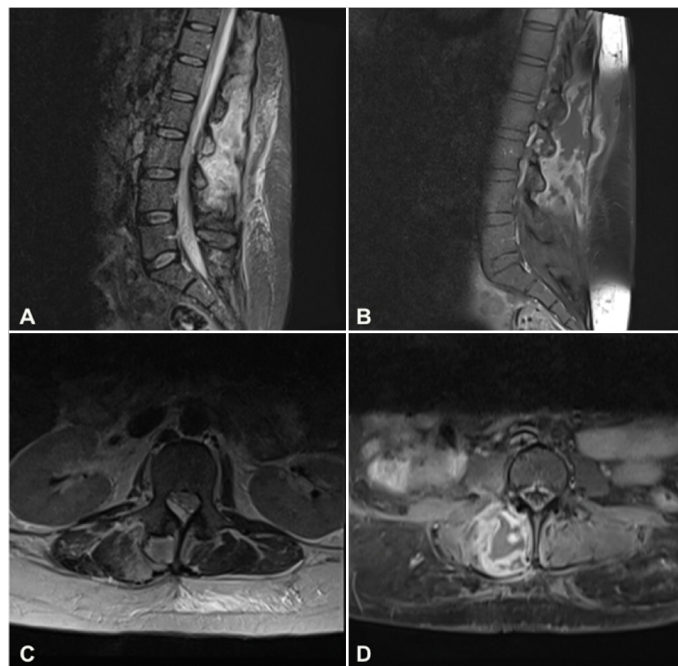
Preoperative magnetic resonance imaging revealed a heterogeneous expansive lesion, predominantly hyperintense on T2-weighted sequences, with irregular peripheral enhancement, located in the right posterior paravertebral musculature, adjacent to the spinous processes from L1 to L4. The lesion measured approximately 47 × 43 × 142 mm (anteroposterior × laterolateral × craniocaudal). Involvement of the L2–L3 and L3–L4 facet joints was observed, with bone marrow edema in the posterior arch elements of L2 and L3. Extension of the lesion into the spinal canal was evident, situated extramedullary, with caudal identification at the level of the L3 vertebral body. The presence of an epidural collection within the spinal canal resulted in compression of the nerve roots, secondary to canal narrowing at the L1–L2 levels (A, B, C, D).
